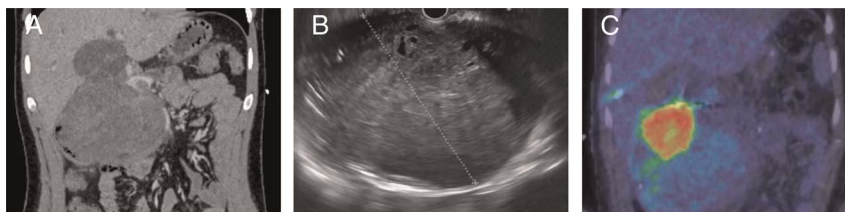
A 28-year-old man presented with general malaise, weight loss, and jaundice. A large palpable mass was discernible in the epigastrium on abdominal examination. Computed tomography scan (A) demonstrated a 12-cm lobulated mass arising from the head of the pancreas causing biliary and pancreatic duct obstruction. EUS (B) demonstrated a heterogeneous soft tissue mass lesion with some cystic foci, and FNB was performed. PET-CT (C) showed intense tracer (¹⁸F-FDG) uptake.
